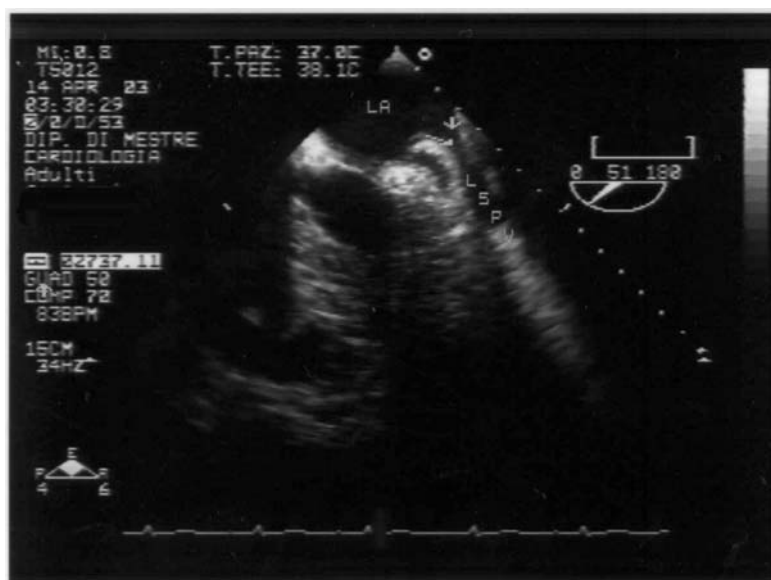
Transoesophageal echocardiography (TEE) image of a pulmonary vein stenosis. The arrows point out the site of the stenosis. LA Left atrium, LSPV left superior pulmonary vein
